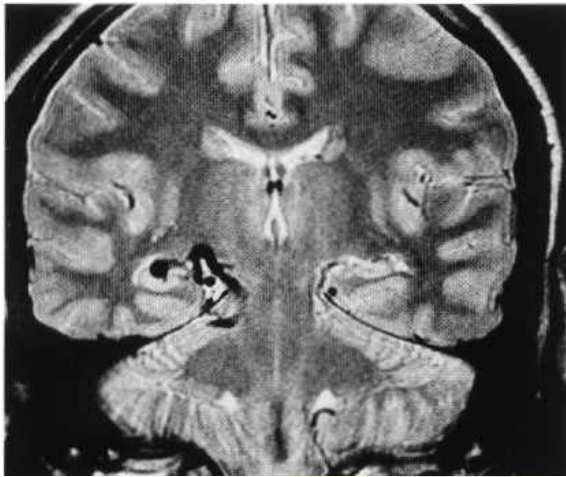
Coronal MRI (T₂-weighted). Abnormal vessels are shown in the right medial temporal lobe involving the hippocampus. Angioma.
